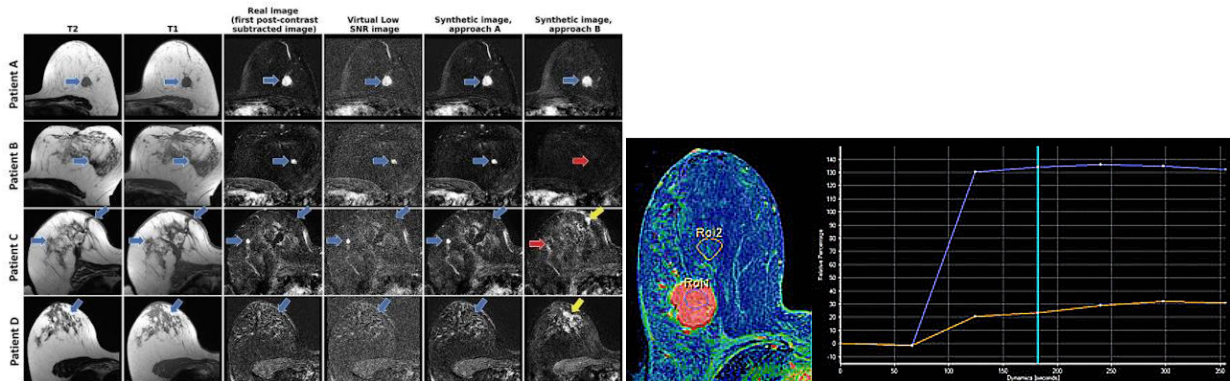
Visualization of breast tumor lesions on real and synthetic magnetic resonance imaging (MRI) images, along with the results of dynamic contrast-enhanced analysis. Rapid increase in signal intensity followed by a “wash-out” pattern is characteristic of malignant processes and contributes to improved diagnostic accuracy of MRI.
